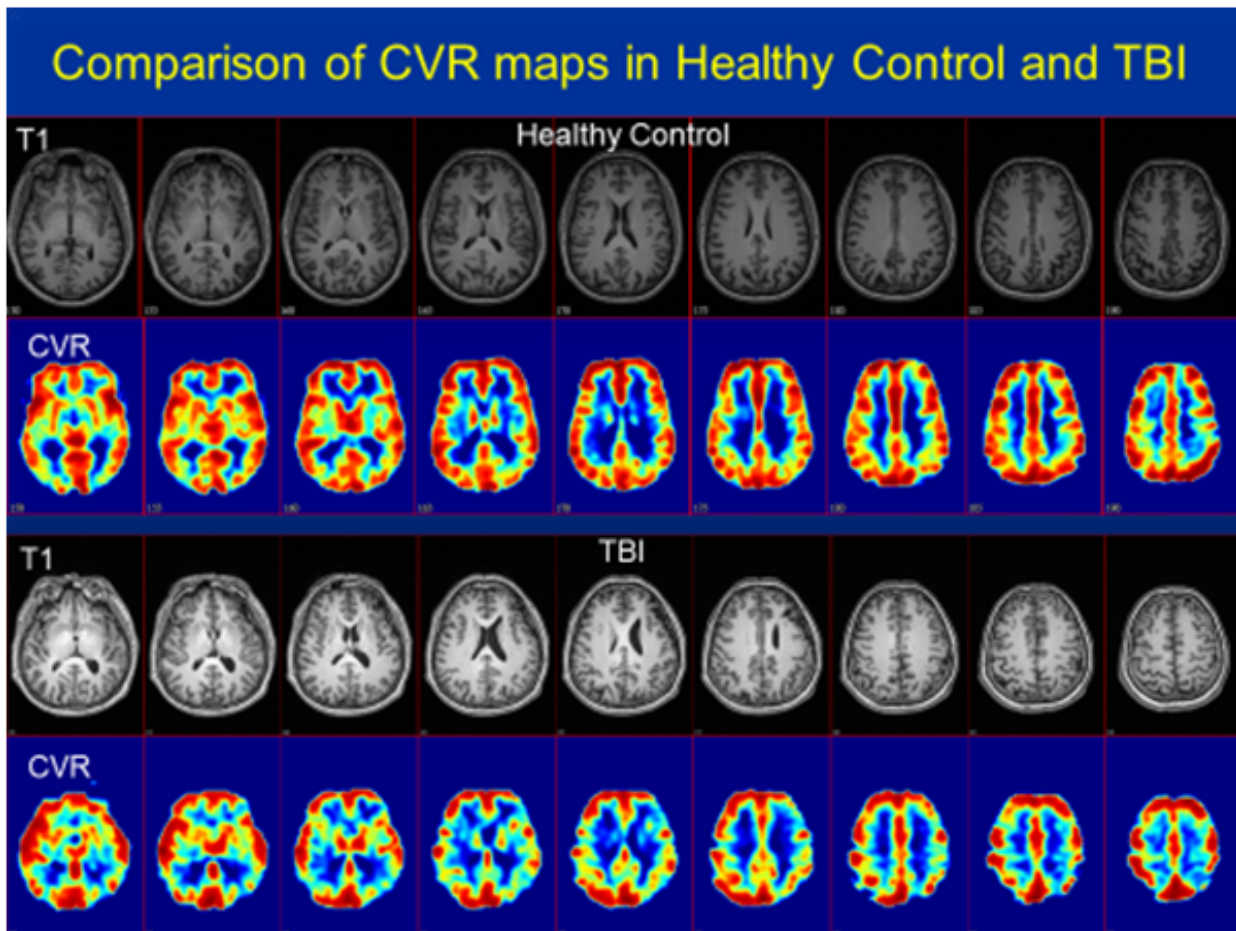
T1 MRI images (rows 1 & 3) with corresponding cerebrovascular reactivity (CVR) maps (rows 2 & 4) based on MRI-BOLD with 5% hypercapnia challenge in a healthy control (top 2 rows) compared to chronic TBI subject (bottom 2 rows). Note the relatively uniform CVR throughout the cortex in the control subject in the top two rows compared to the patchy, moth-eaten appearance to the CVR maps from the TBI subjects. As expected, in areas of visible encephalomalacia, the CVR was decreased. However, there were also many regions where the CVR was depressed but the structural MRI was normal. Ref: Courtesy of Franck Amyot, Ph.D., CNRM, USUHS.
